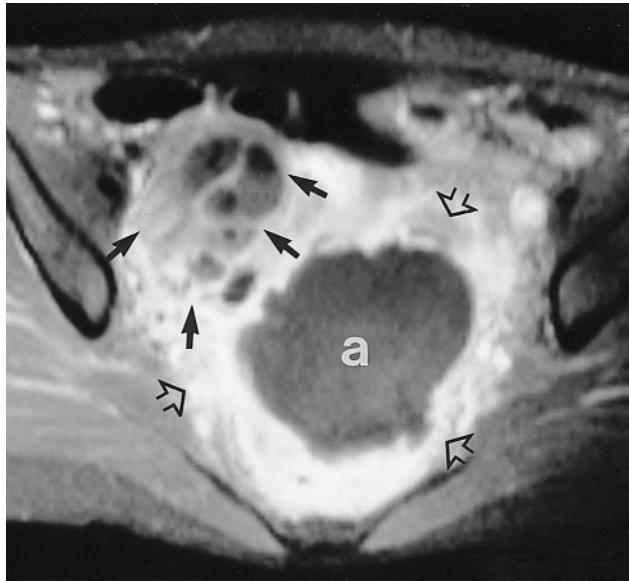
Tubo-ovarian abscess. Transverse gadolinium-enhanced T1-weighted fat-suppressed SE image in a woman with fever and a fluctuant adnexal mass on bimanual exam. A large loculated abscess occupies the posterior pelvis (a). The right ovary is enlarged (solid arrows) and is invested with an abscess ("a"). The well-formed abscess capsule and septations enhance markedly, as does the inflammation in the surrounding fat (open arrows). Associated inflammatory changes are more conspicuous on fat-suppressed images. Tubo-ovarian abscess is a well-recognized complication of PID, and whereas most cases of PID can be managed conservatively, the presence of an abscess usually necessitates surgical intervention.
